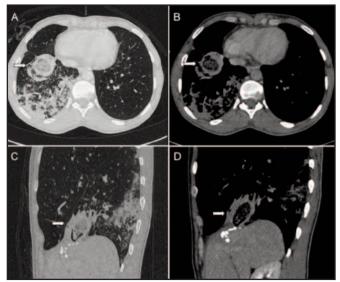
Selected CT images in axial and sagittal views in both lung and soft tissue window settings.
